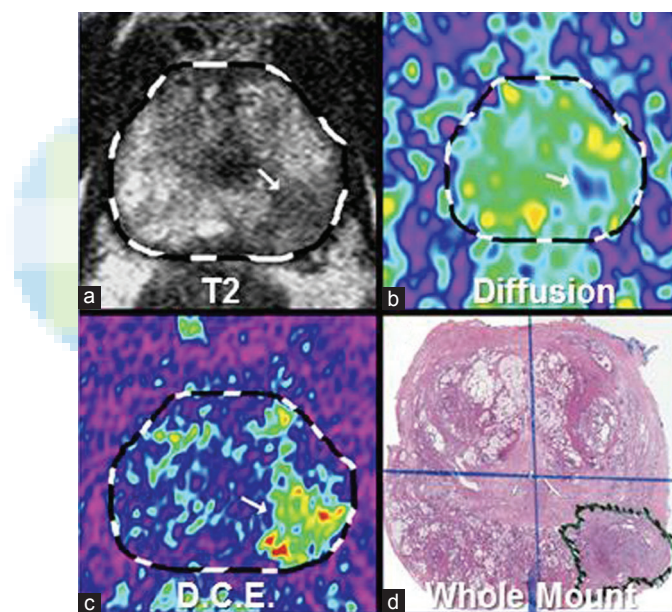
Multiparametric magnetic resonance imaging of a left peripheral prostate gland lesion on T2-weighted imaging (a), diffusion-weighted imaging (b), dynamic contrast-enhanced (c), and on whole mount pathology (d). Arrow directed toward lesion.
